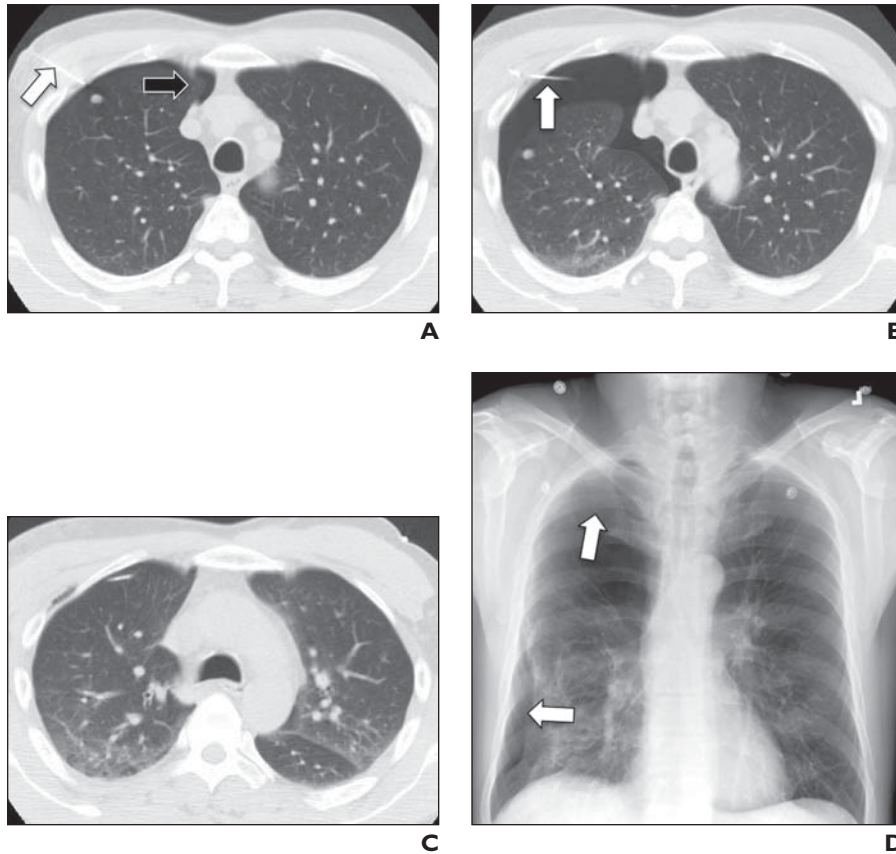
50-year-old man undergoing biopsy of 8-mm right upper lobe pulmonary nodule. A, Soon after biopsy needle (white arrow) was placed, pneumothorax (black arrow) developed. Pneumothorax enlarged and was interfering with targeting. B, Therefore, 5-French catheter (Yueh Centesis, Cook Medical) was placed in pleural space (arrow) and air was aspirated to allow procedure to be completed. C, At end of procedure, air was again completely aspirated, tube was removed, and patient was observed in recovery unit. D, Follow-up chest radiograph obtained 2 hours after biopsy reveals significant pneumothorax (arrows) has developed; also, patient was having increased difficulty breathing. Therefore, chest tube was placed and patient was admitted to hospital.
